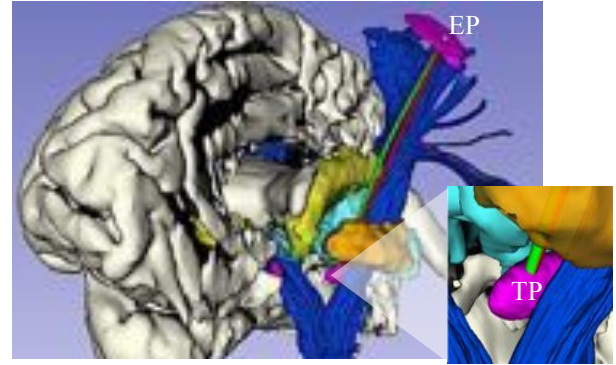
Planning case on the left hemisphere. RT (red) and CT (green) are shown. EP is located on the purple EA, while TP is placed within the left one of the STN (fuchsia). The picture shows THA (cyan), GP (brown), CN (yellow) and CST (blue).
